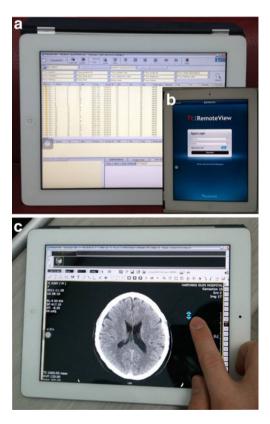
A* The remote-controlled PACS worklist on the iPad; *B* the login screen of the RemoteView application on the iPad; *C* observers viewed the remote-controlled PACS CT images on the iPad by touching and scrolling the screen
